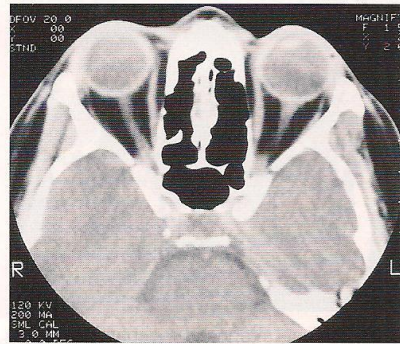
Axial computed tomogram of the same patient showing no apparent orbital mass.
